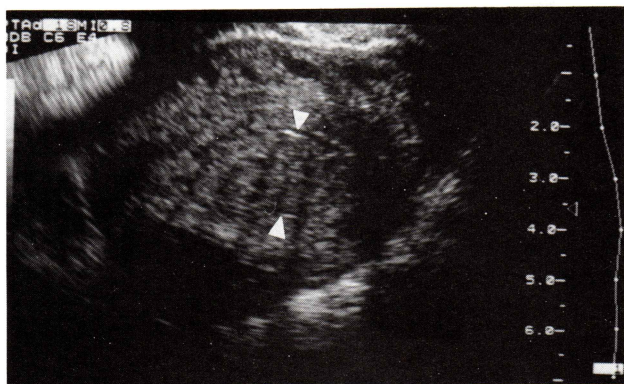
Conventional transvaginal sonography demonstrated an thickened endometrial interface (arrow) in a patient who presented with abnormal vaginal bleeding.
